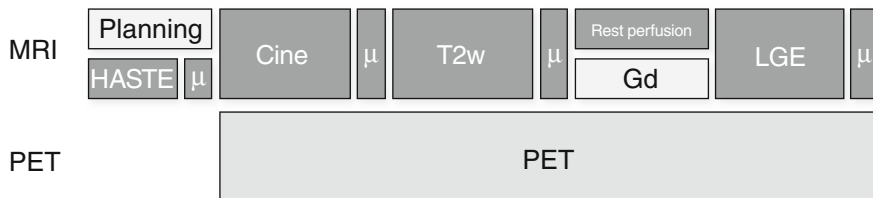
Basic protocol for simultaneous cardiac PET/MR imaging. *HASTE* axial 2D half Fourier acquisition single-shot turbo spin echo sequence, μ attenuation map (μ -map) using 2-point Dixon sequences, *Cine* Cine imaging using balanced SSFP sequence, *T2w* T2-weighted imaging using turbo inversion recovery magnitude sequence, *Rest Perfusion* rest perfusion imaging using saturation recovery fast low-angle shot sequence, *Gd* ~10 min waiting for late gadolinium enhancement, *LGE* late gadolinium enhancement imaging using segmented 2D inversion recovery turbo FLASH sequence
